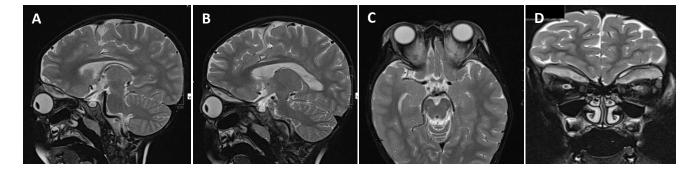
T2 weighted MRI sequences of the sagittal planes of (A) right and (B) left eyes, and (C) axial and (D) coronal planes of the head and orbits show the predominantly hypointense masses occupying the superior extraconal regions of both orbits.
